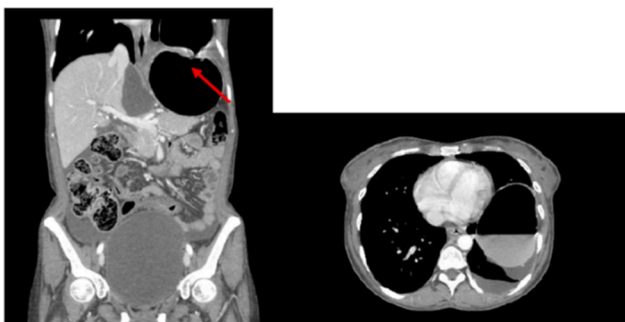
Computed Tomography (CT) scan: left diaphragmatic hernia with incarceration of stomach in the chest (arrow).
